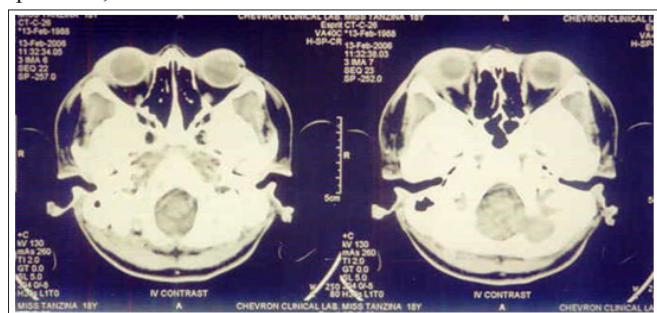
CT scan of orbit showed orbital mass in superolateral orbit
